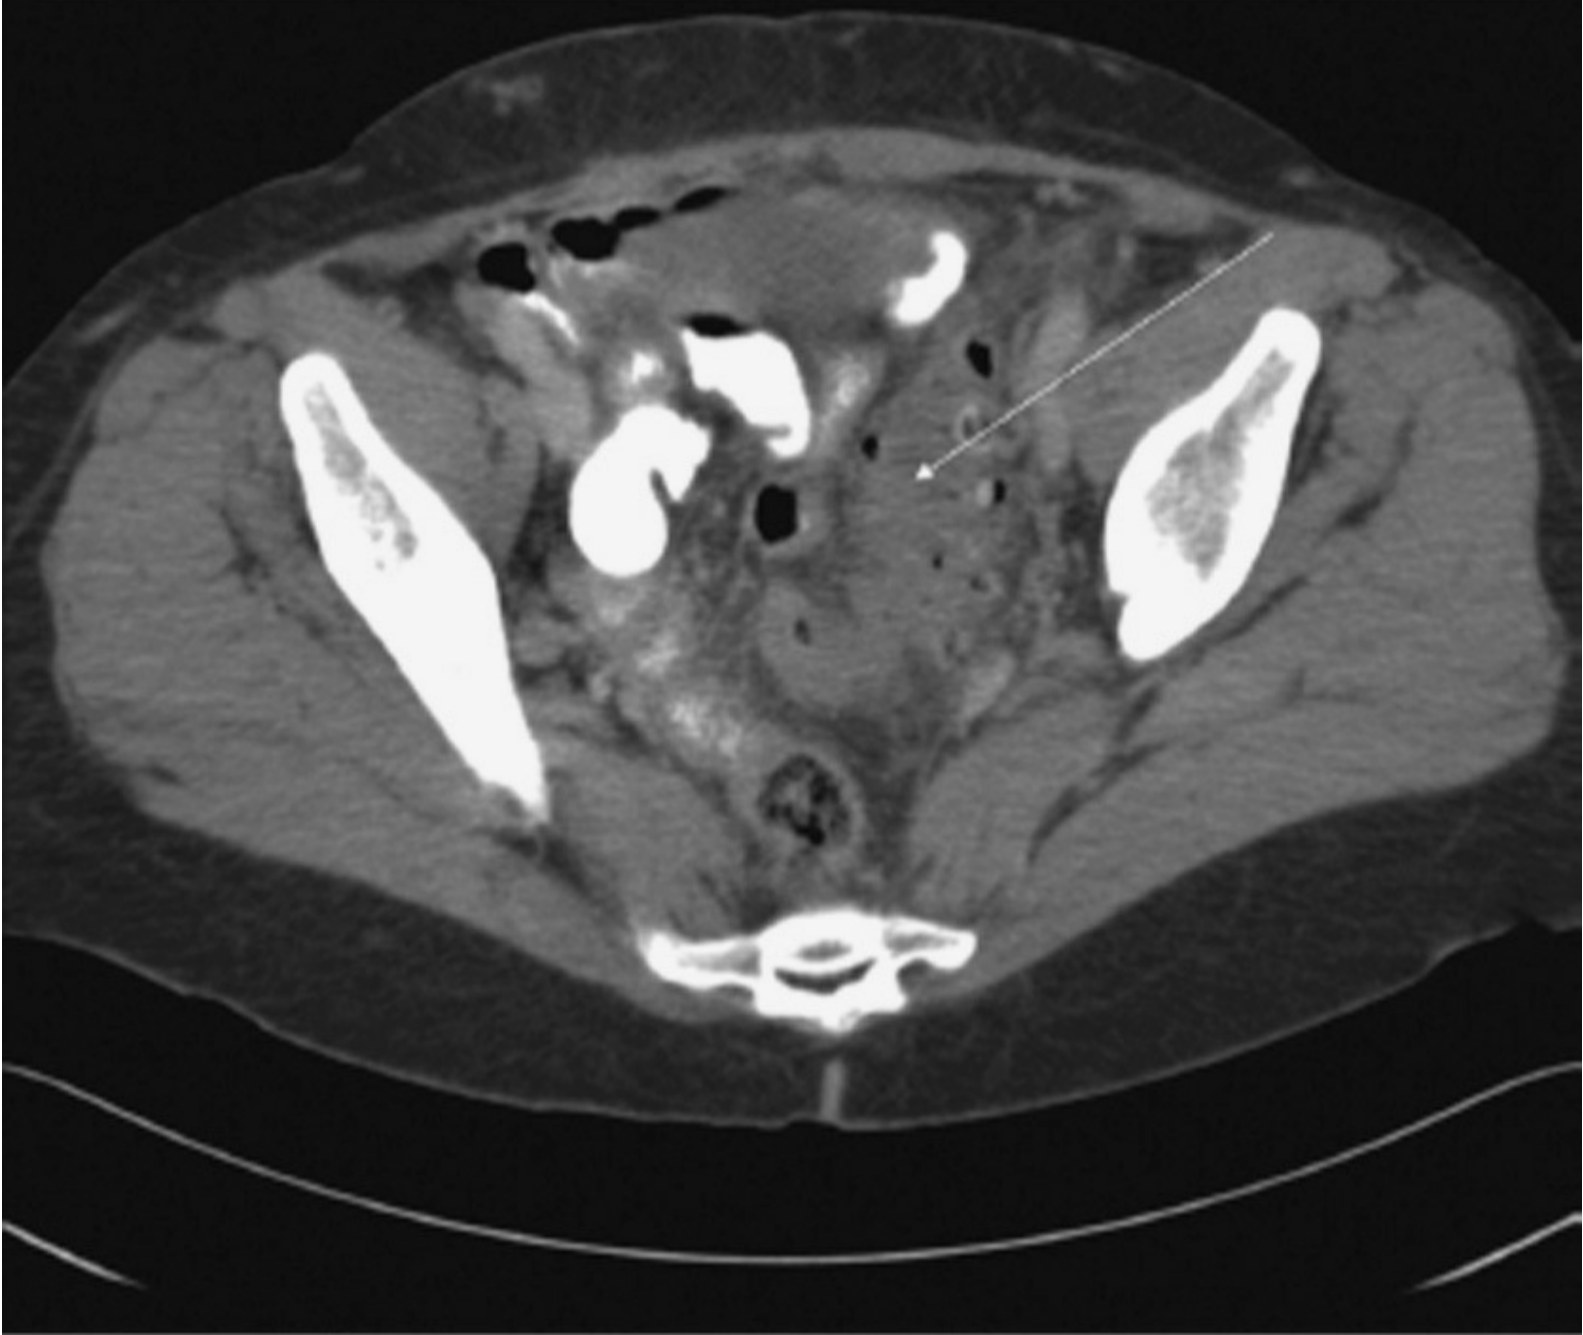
Computed tomography scan of the abdomen with left lower quadrant abdominal pain showing sigmoid colon mural thickening, several colonic diverticula, and associated mesocolic fat infiltration, which are findings consistent with acute diverticulitis. (Reproduced, with permission, from McKean SC, Ross JJ, Dressler DD, et al, eds. *Principles and Practice of Hospital Medicine*. New York: McGraw-Hill; 2012.)
